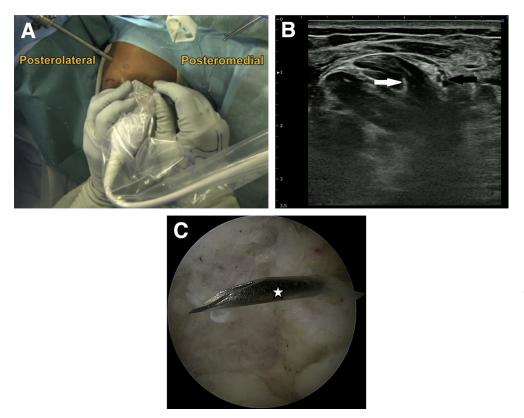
Simultaneous pictures of the initial steps in ultrasoundassisted posteromedial portal placement. (A) Top view image of the left posterior elbow joint with the patient in prone position. A linear probe is held to view the short axis of the ulnar nerve. A pilot needle is slowly inserted inside the posteromedial elbow joint radial to the viewed ulnar nerve. (B) Short-axis real-time ultrasound image of the ulnar nerve (black arrow) and pilot needle (white arrow). The needle is inserted into the posteromedial elbow joint. (C) Corresponding arthroscopic image taken from the posterolateral viewing portal, showing insertion of the pilot needle (star) into the posteromedial elbow joint as a guide to create the posteromedial portal.
